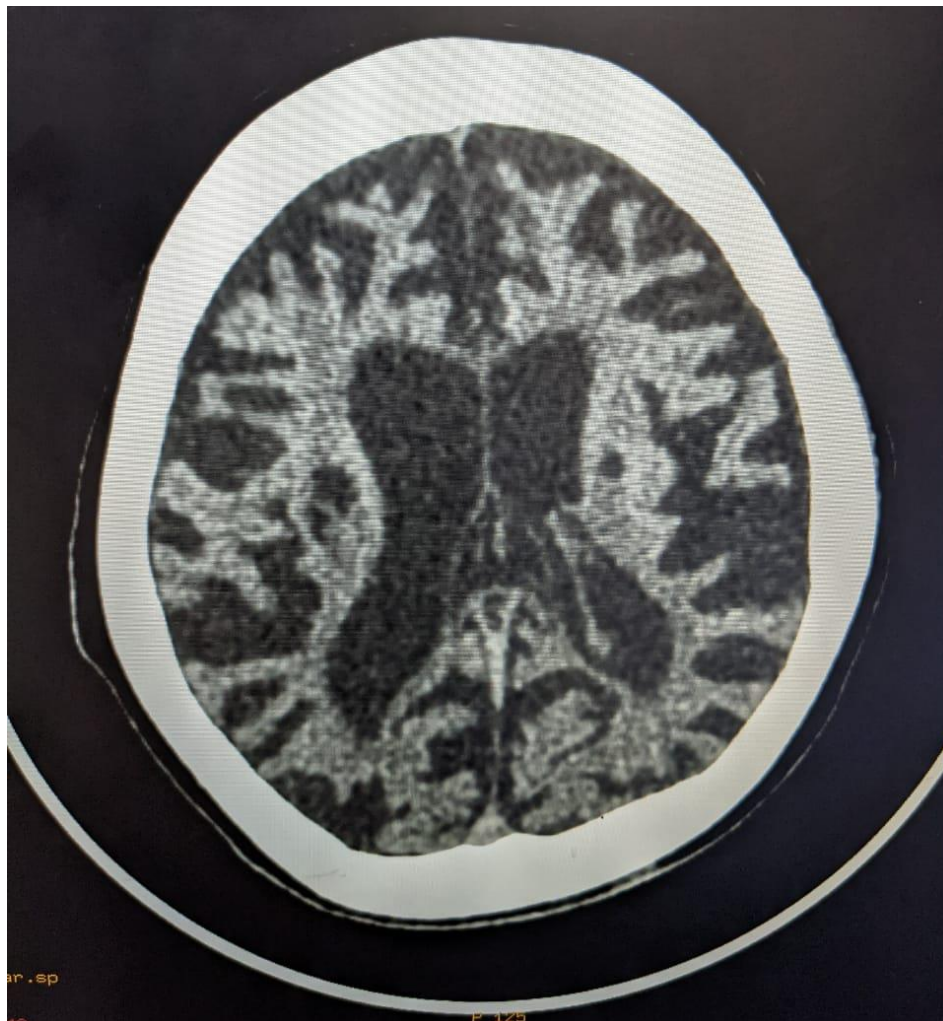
Computed Tomography picture.
